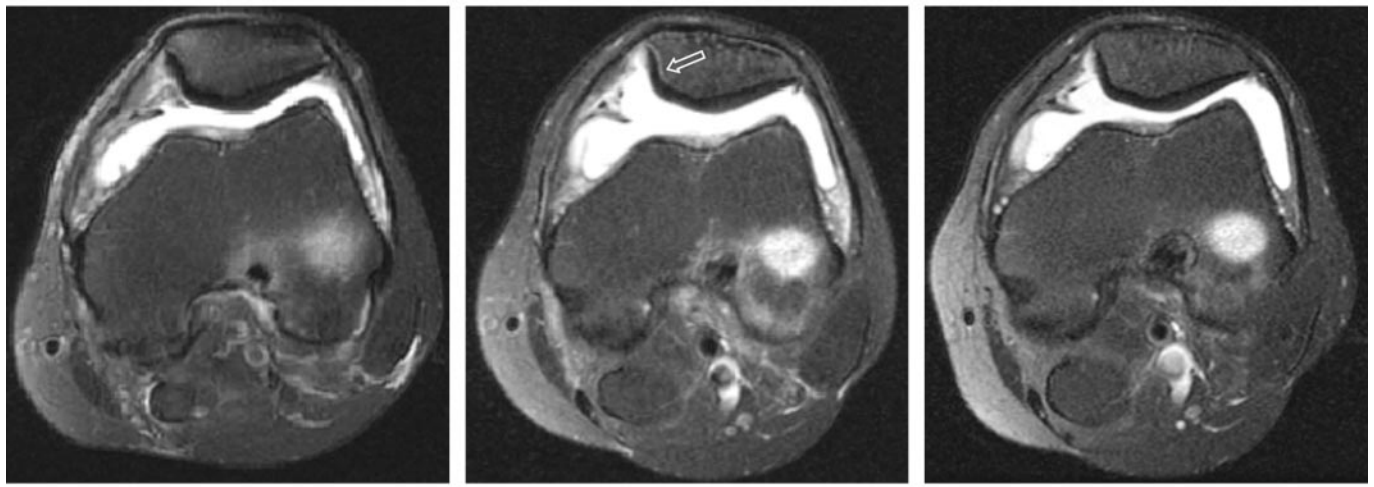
Transverse T2-weighted fast SE MR images obtained with fat saturation (3500/68.4) at (a) 6, (b) 12, and (c) 24 weeks after ACL graft reconstruction in a 31-year-old man. Increased peripheral T2-weighted signal intensity (arrow) in the subcortical part of the patella is seen only in b.
